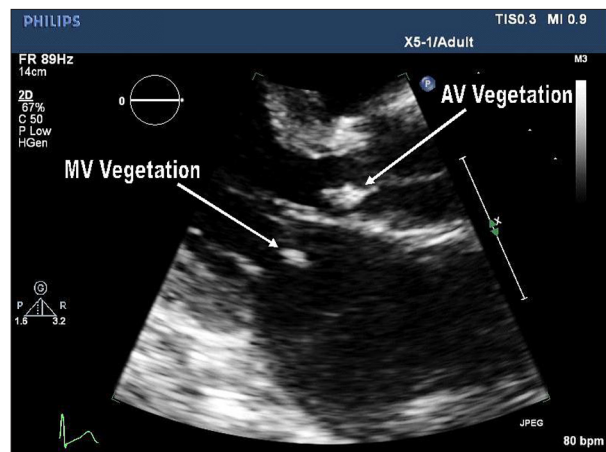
Parasternal long axis echocardiogram view of mitral valve and aortic valve vegetations.
